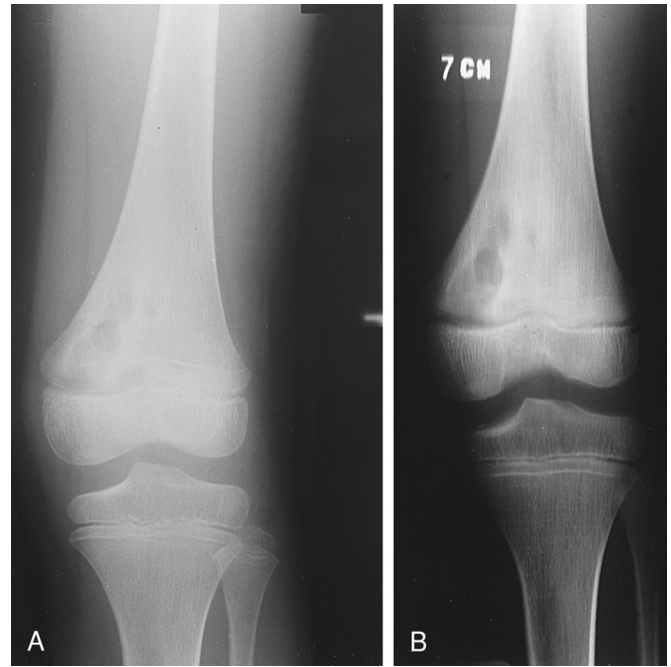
A, Anteroposterior radiograph of the distal femur in a 12-year-old girl with limping and nighttime knee pain for 6 months. There is a lucent lesion with surrounding sclerosis in the metaphysis. The lesion crosses the epiphysis; this is characteristic of a subacute osteomyelitis. B, Anteroposterior tomography clearly demonstrates the lucent nature of the lesion and its surrounding sclerosis.
